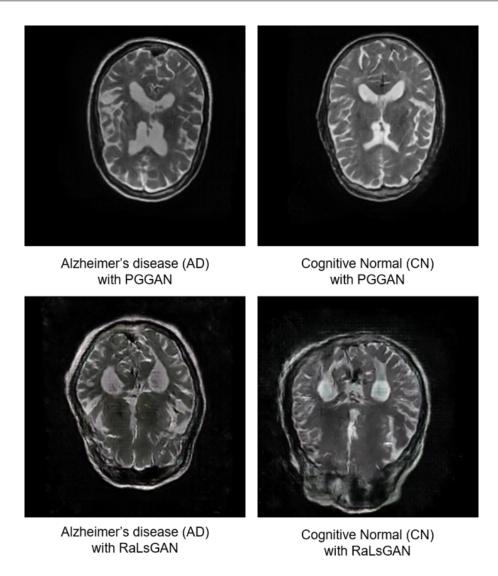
Comparison of MRI images generated by PGGAN-WP and RaLSGAN
